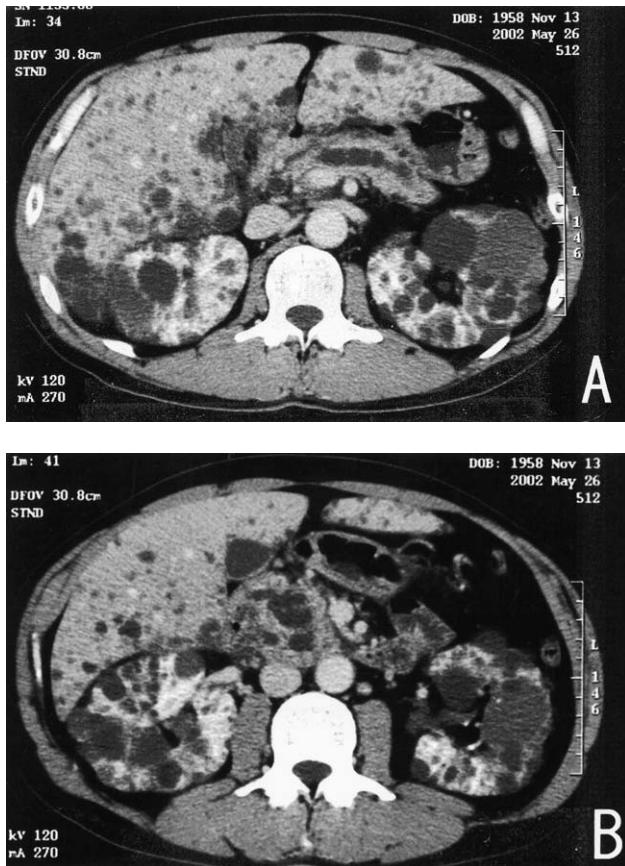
CT images of the abdomen show (A) multiple cysts in the liver and both kidneys, and a main pancreatic duct that is 1 cm in diameter, and (B) a cystic mass, 4 cm in diameter, in the head of the pancreas.
